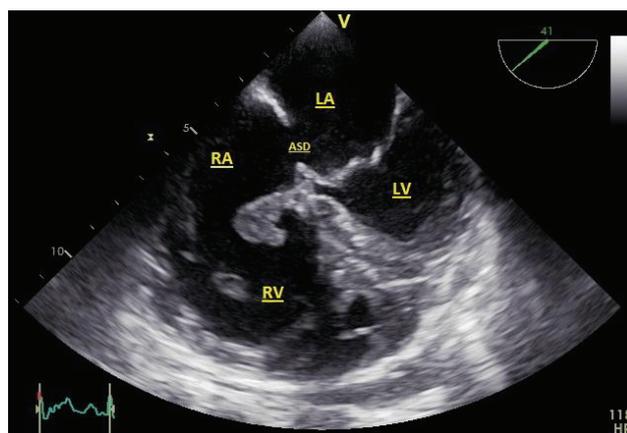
Transesophageal echocardiography of four chambers shows atrial septal defect (ASD), type primum. Mitral and tricuspid valve orifices are in the same level. Vegetation is connected to the septal leaflet of the tricuspid valve floating between right atrium (RA) and right ventricle (RV) through the tricuspid valve. LA – left atrium; LV – left ventricle.
